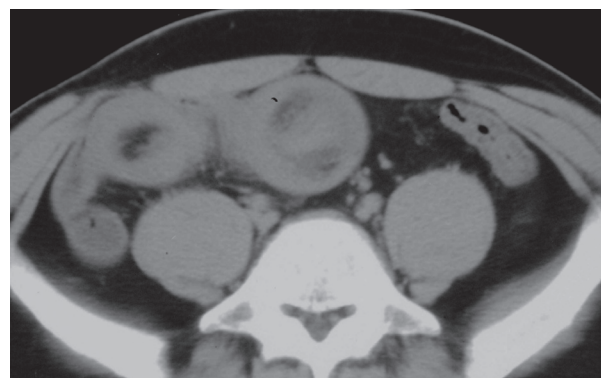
Abdominal CT scan showing the characteristic "target lesion" in the right lower abdomen indicating intussusception, which proved operatively to be due to Meckel's diverticulum (Case no. 5).
